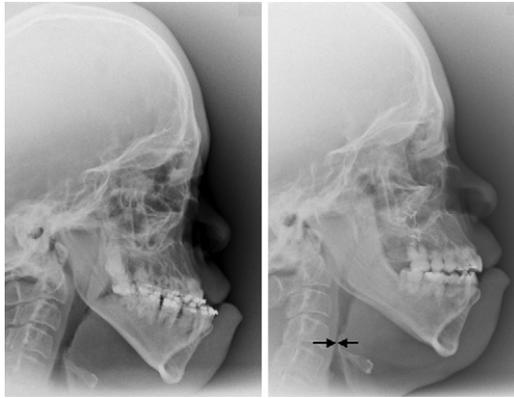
Lateral skull radiographs of a patient with Crouzon syndrome (A) before and (B) after Le Fort III DO. Naso-endoscopy revealed residual OSA on level of the oro-/hypopharynx which can be seen in B (arrow).
